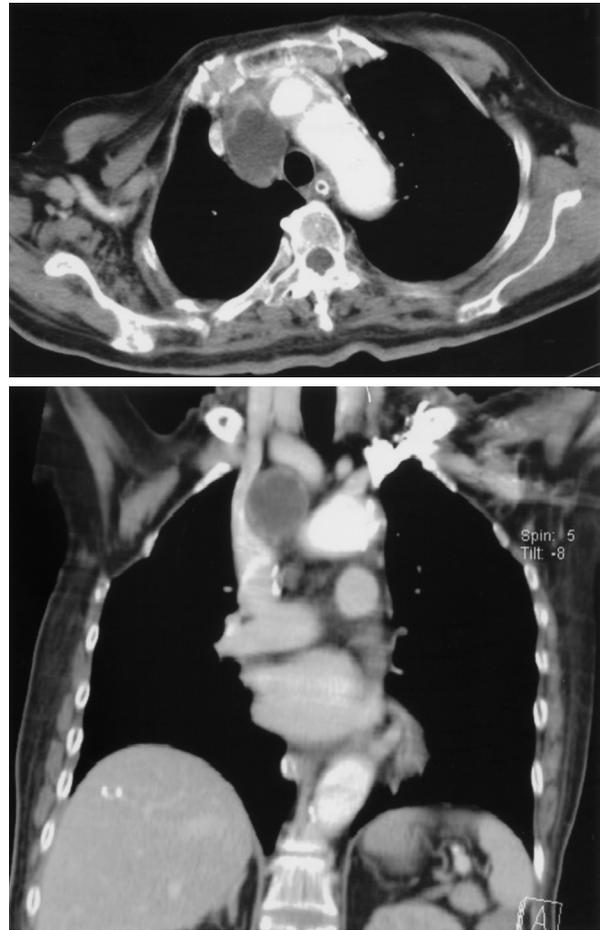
Chest computed tomography scan revealed a 3.2×2.7×3.5-cm soft tissue mass with central low density in the right superior anterior mediastinum and abutting the superior vena cava.
